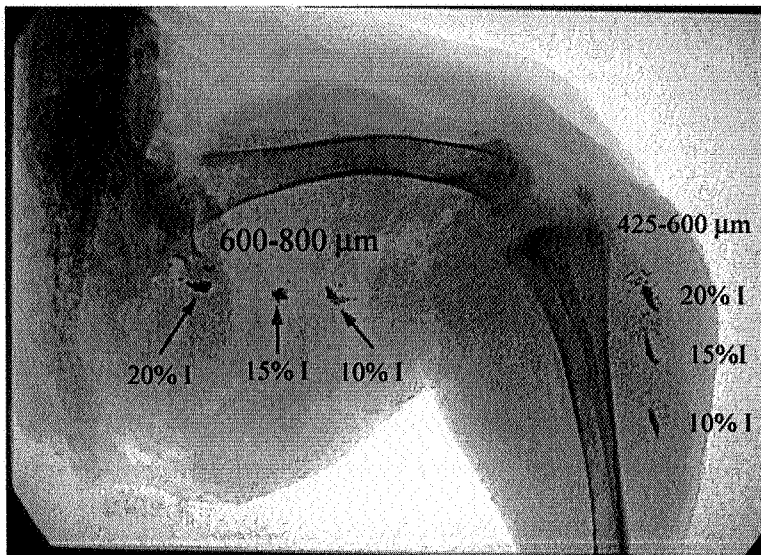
X-ray images of radiopaque microspheres
